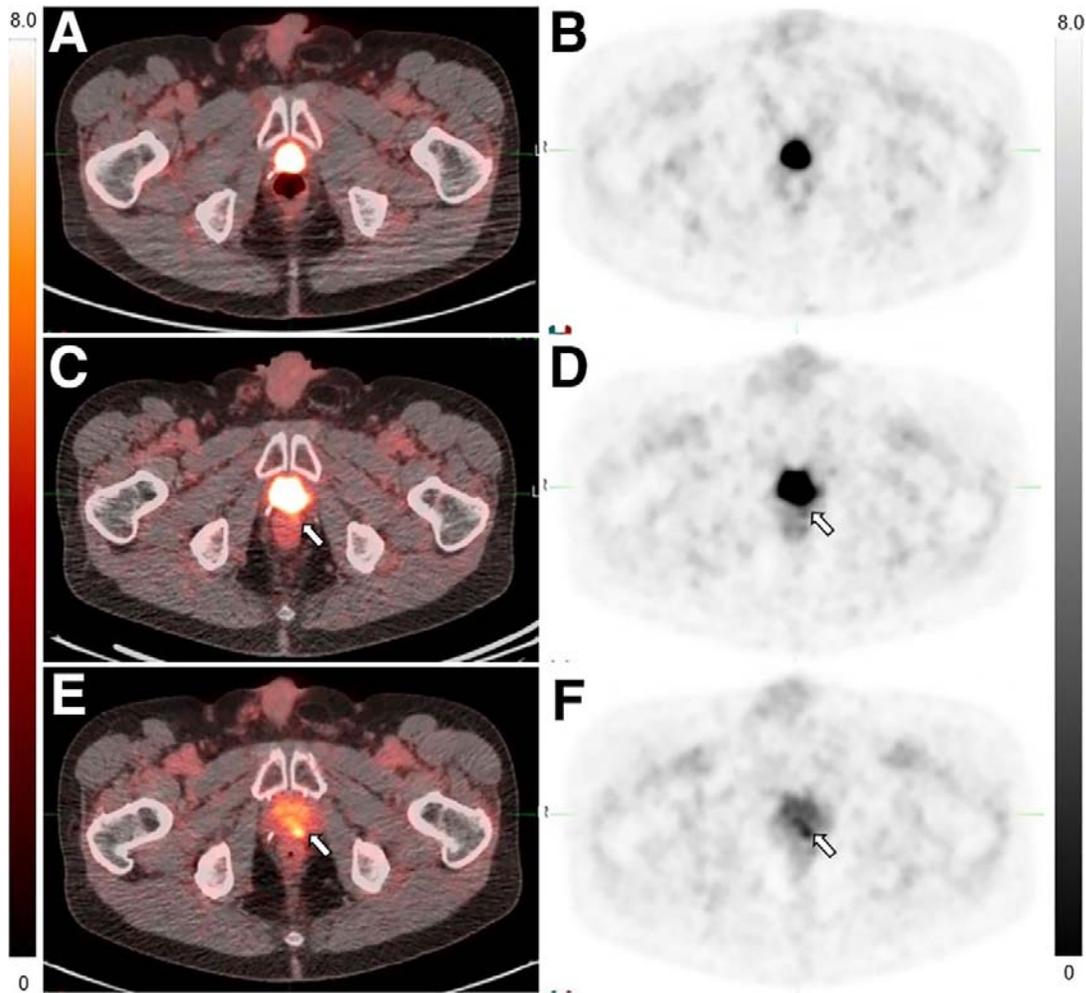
An 83-y-old man with PSA of 0.60 ng/mL after radical prostatectomy received clinical ^{18}F -piflufolastat (^{18}F -DCFPyL) PET/CT imaging (A and B), which failed to localize site of recurrence. He was subsequently enrolled in this phase II study. Initial ^{18}F -flotufolastat PET/CT without furosemide (C and D) was interpreted as negative. ^{18}F -flotufolastat PET/CT with furosemide demonstrates left retrovesicular focus of increased radiotracer uptake with SUV_{max} of 6.3 consistent with prostate bed recurrence (arrows in E and F). In retrospect, lesion was visible in left retrovesicular region on without-furosemide study (arrows in C and D) though obscured by bladder activity.
